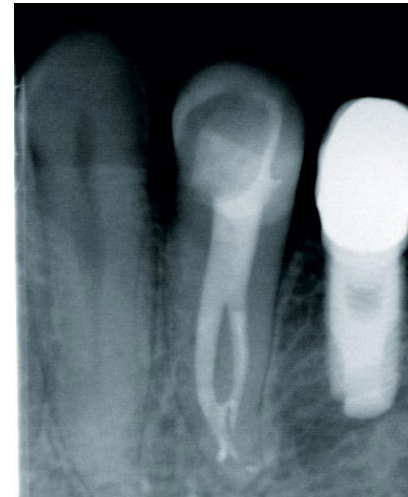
Radiographic control of tooth 34 after root canal obturation
